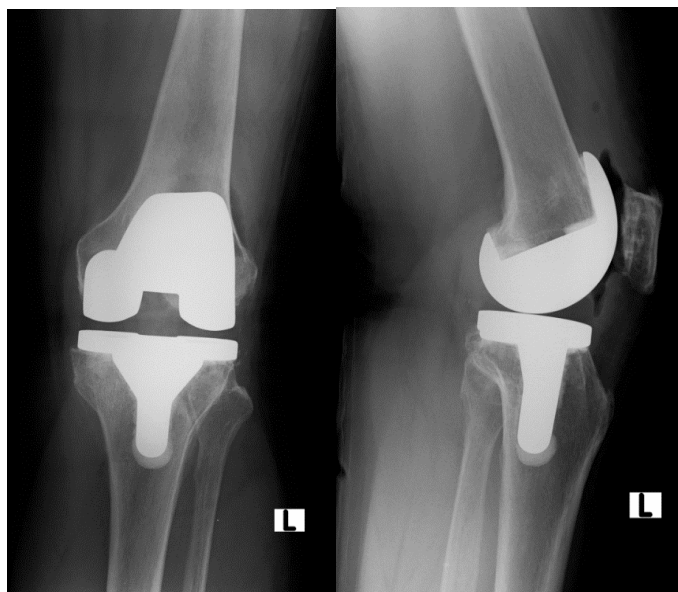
Knee Radiographs Examination Following Patellar Resurfacing Procedure
